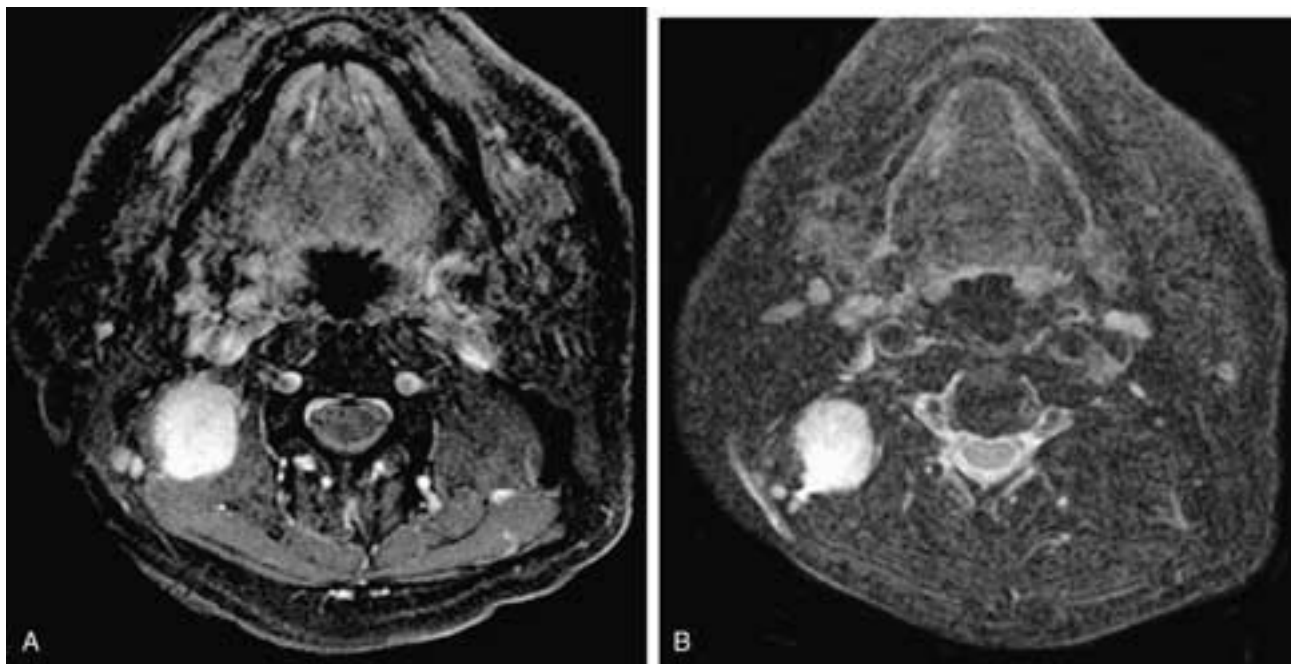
Axial T2-weighted MR image (A) shows a hyperintense nodule in the right paraspinal muscles. Axial T1-weighted, fat-suppressed, contrast-enhanced MR image (B) shows an intensely enhancing nodule. The appearance is not specific, as a primary muscle tumor or metastasis could have a similar appearance. This patient had nodular fasciitis.
